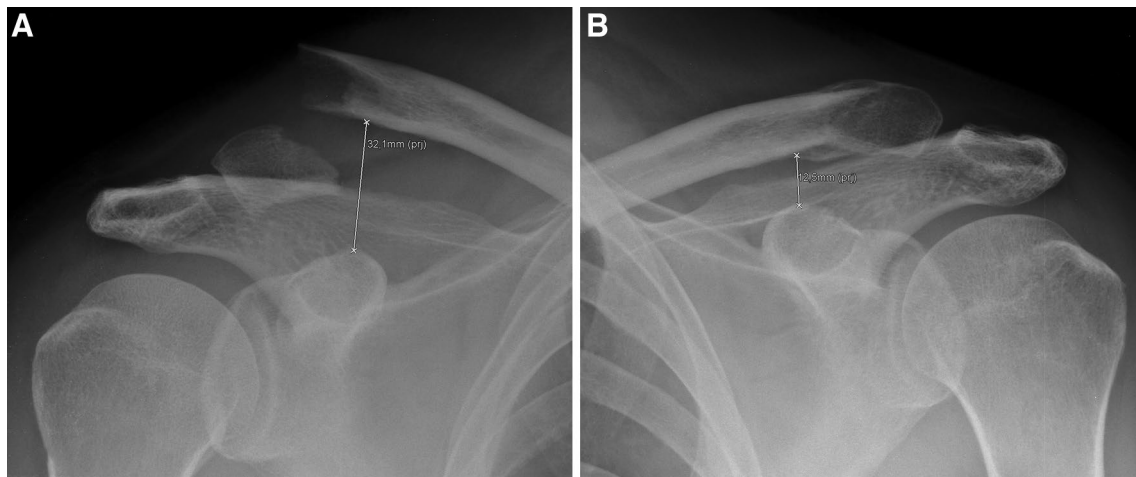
Preoperative bilateral anterior–posterior stress radiography with 10 kg vertical loading shows distinct coracoclavicular instability of the affected side (a) compared to the healthy side (b). The coracoclavicular distance is increased by 157%
